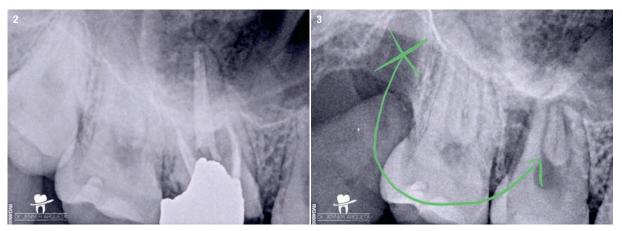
Periapical radiograph of the maxillary right molar. Tooth #18 was to be transplanted to the site occupied by tooth #16. Fig. 3: Tooth #18 transplanted to the site previously occupied by tooth #16.
